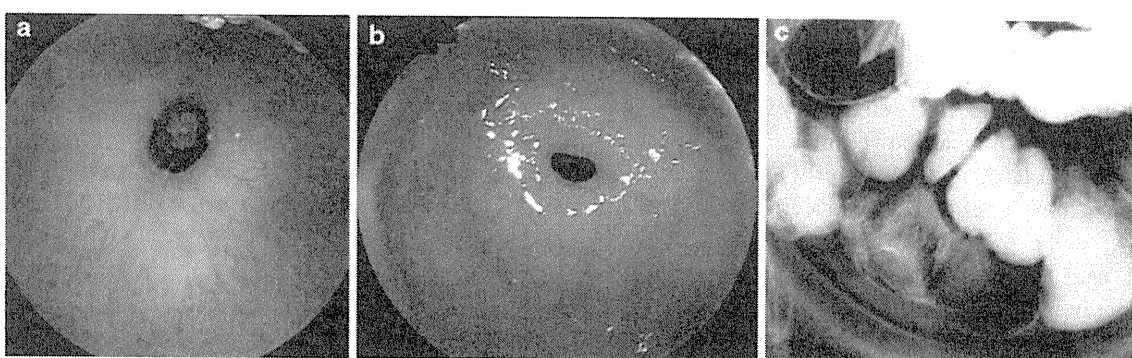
Enteroscopic and radiographic findings of a case of diaphragms in the ileum. A 72-year-old female had been taking diclofenac for rheumatoid arthritis for 24 months, during which repeated abdominal pain occurred. VCE (a) and anal BAE
